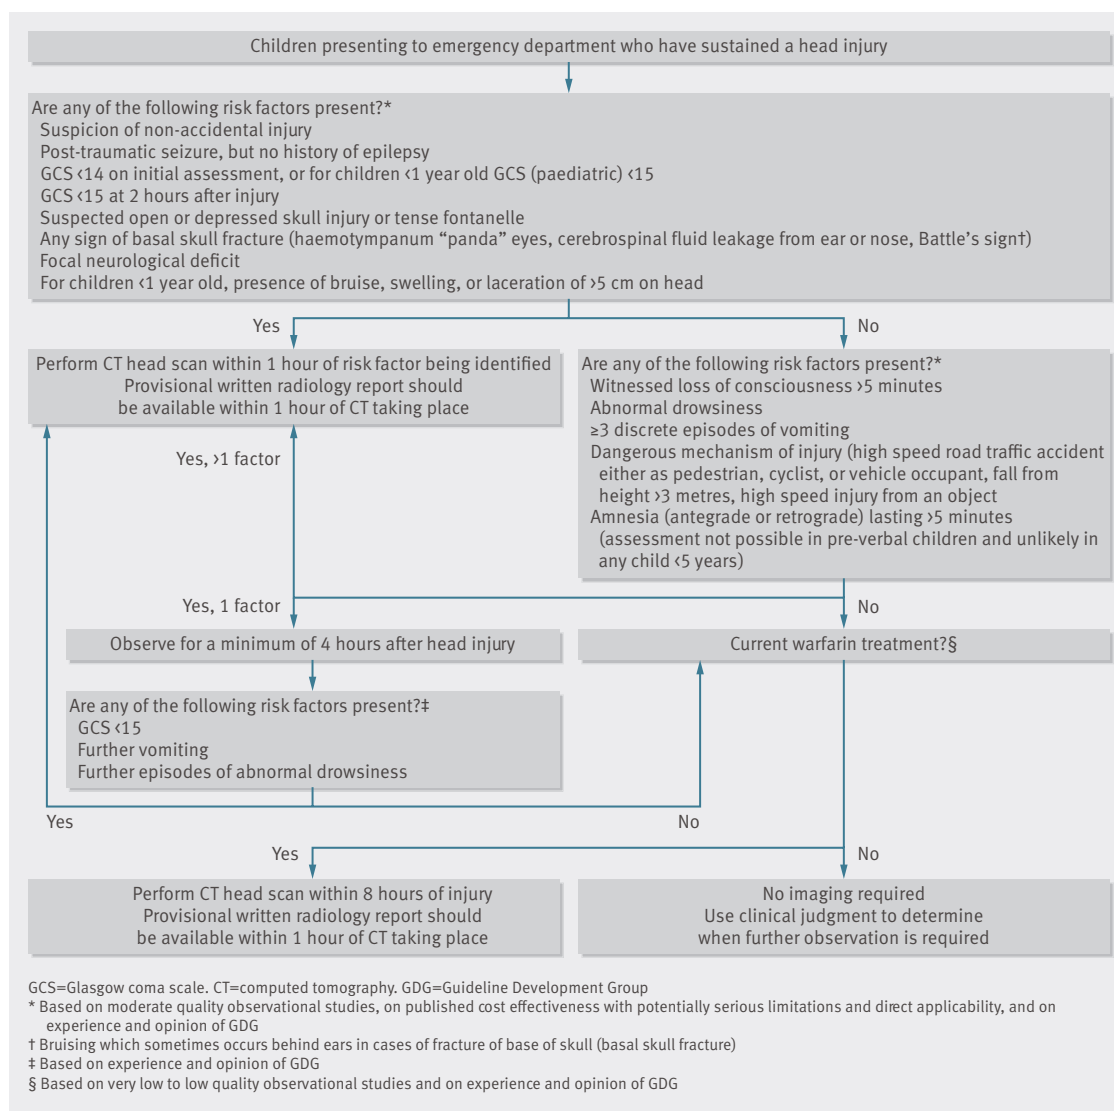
Algorithm 2: selection of children for CT head scan
